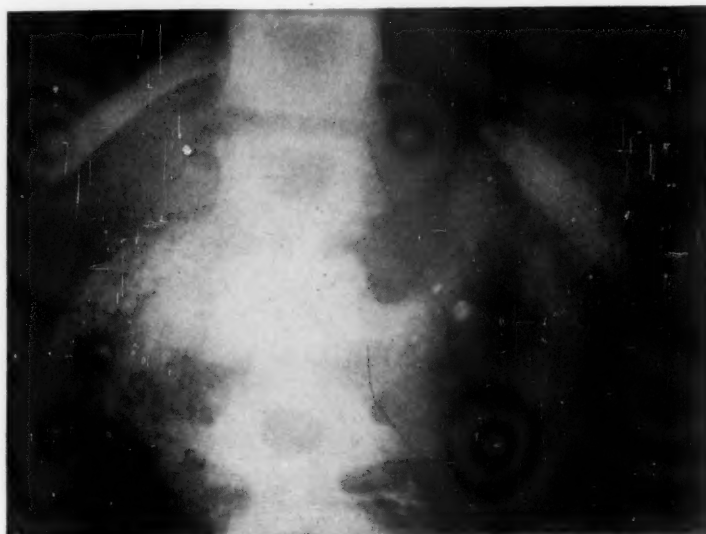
Six-hour roentgenogram showing barium streaked hair ball lying within the empty stomach.
